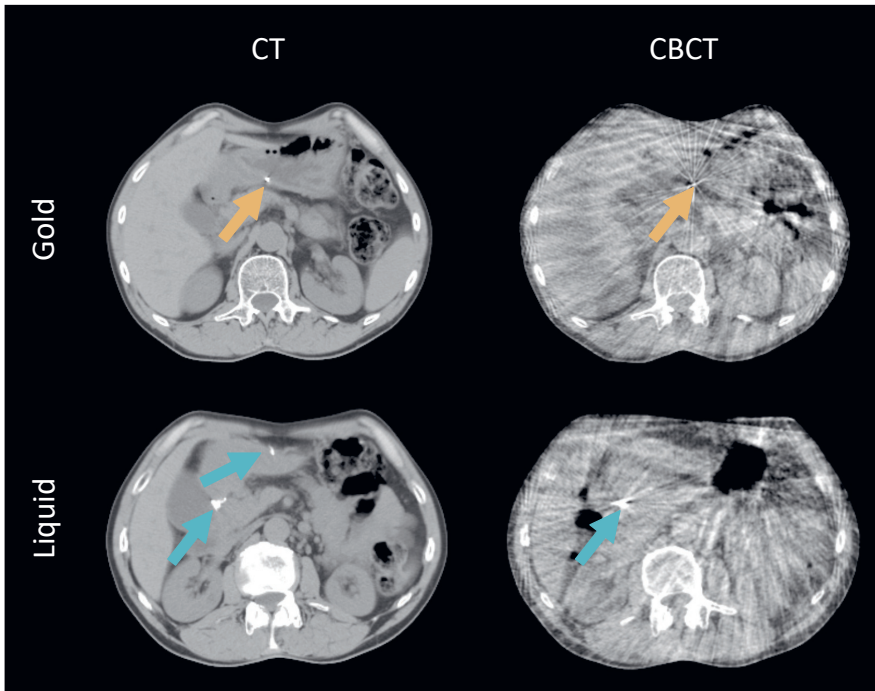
Typical example of gold (orange arrows) and liquid (blue arrows) fiducial markers on CT and CBCT. On the CTs, two liquid markers are visible; one of the two was, although present, not visible on the CBCTs.
